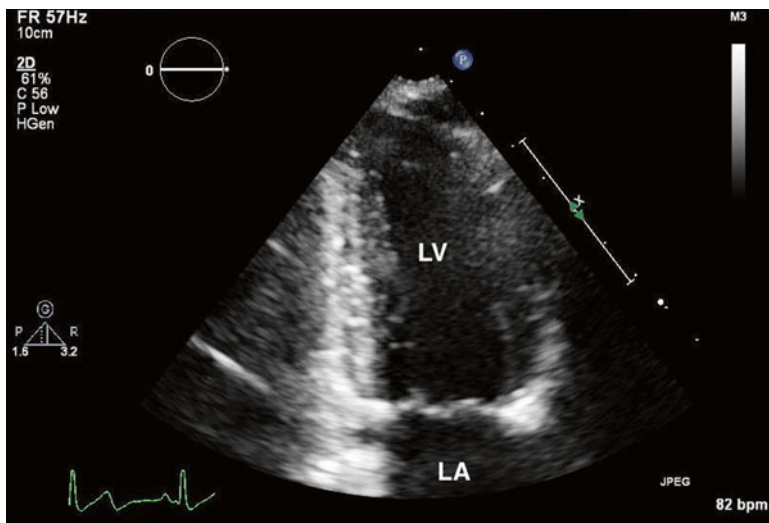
Apical two-chamber view. Clockwise rotation from the apical long-axis view results in a two-chamber image. The entire anterior and inferior walls of the heart are visualized, along with the mitral valve. Left ventricle (LV). Right ventricle (RV)
